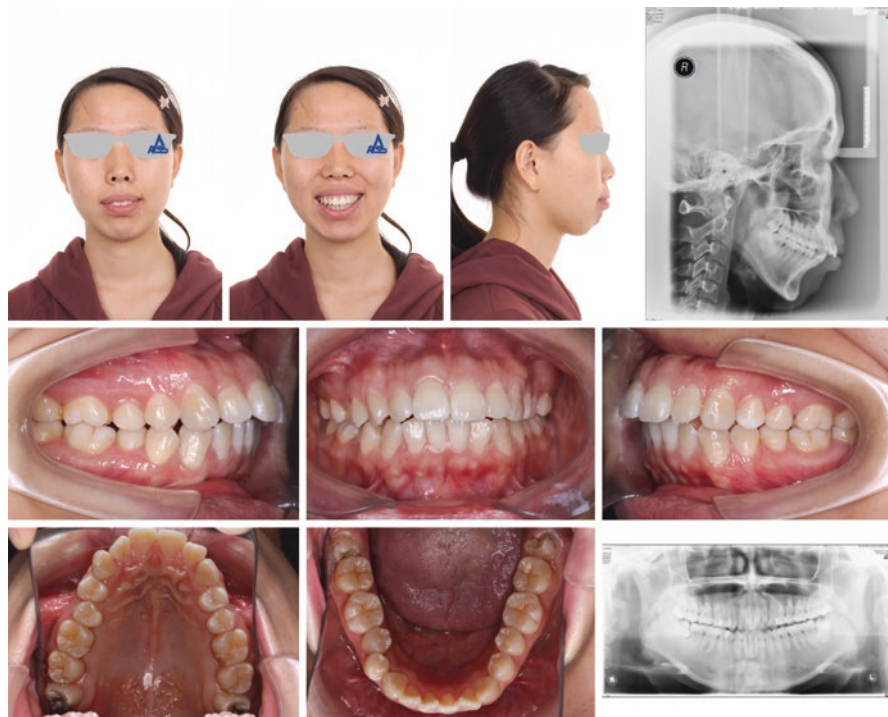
Pretreatment photos, lateral cephalogram, and panoramic radiograph
